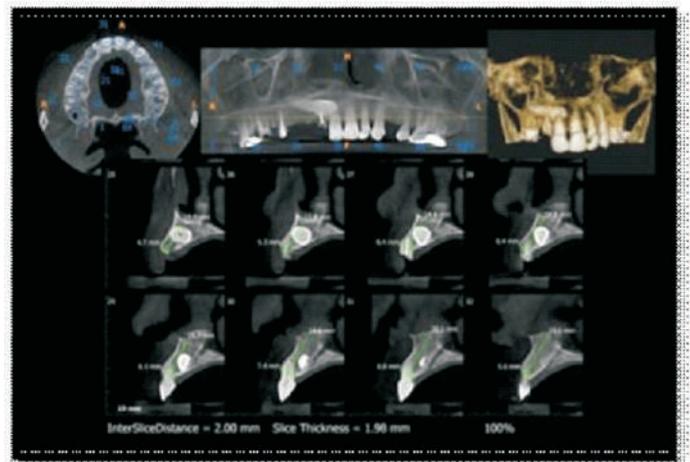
CBCT of patient
